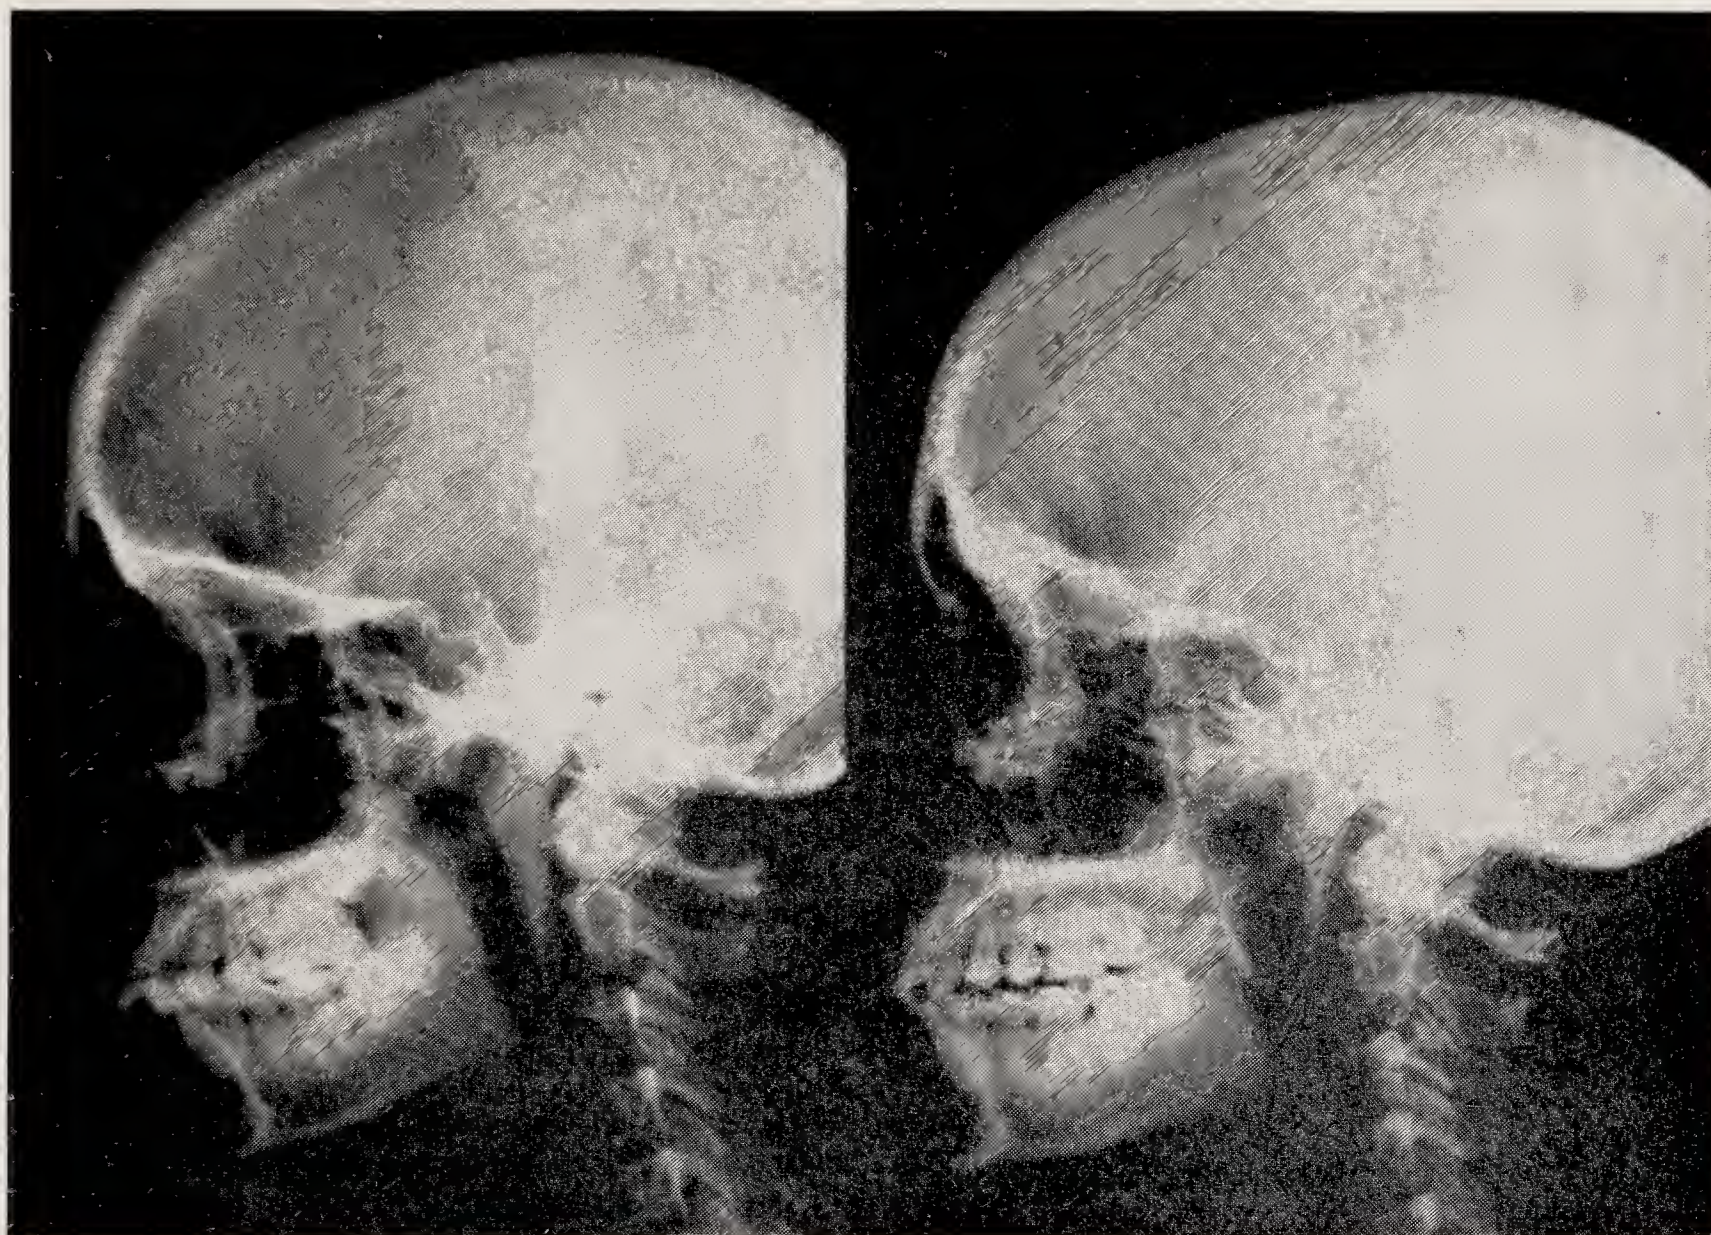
Shows the lateral radiograph in occlusion before treatment and lateral radiograph in the forward posturing after treatment.
